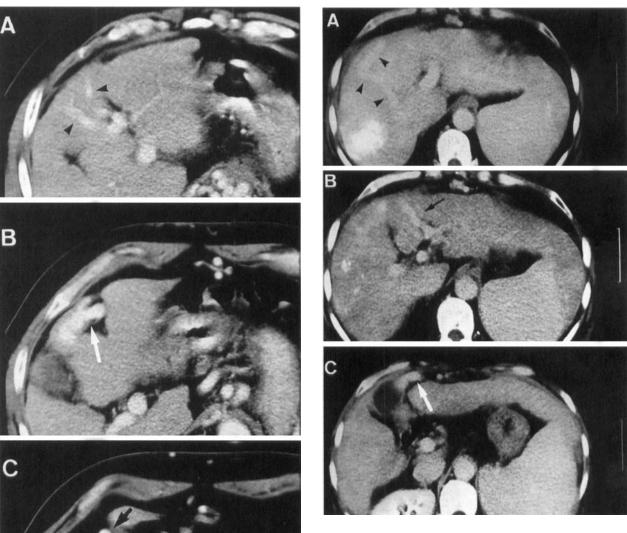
Contrast-enhanced computed tomography (CT) findings of case 5. (a) Unusual intrahepatic collateral vein originating from the right portal vein (arrowhead) runs anteromedially in the hepatic parenchyma. (b) This shunt vein joins with the collateral vein from the left portal vein (black arrow) in the medial segment of the liver (c) and forms one paraumbilical vein (white arrow).
